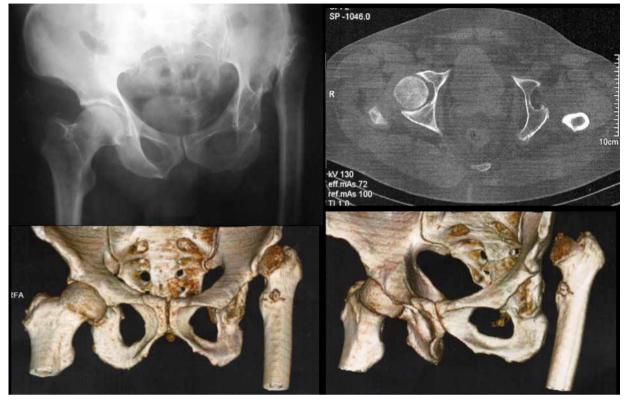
The use of hip radiographs and CT/3DCT scan can accurately classify the deformity and predict the acetabulum bone deficiencies in order to select the proper reconstruction method and implants according to the type of DDH.
